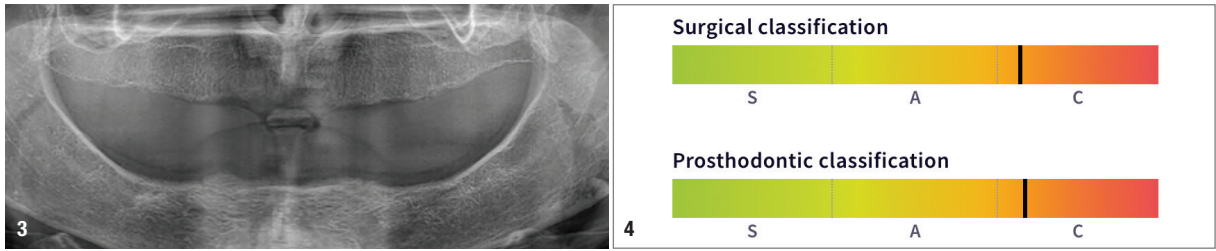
Initial radiographic evaluation by dental panoramic tomogram. Fig. 4: The SAC classification of the treatment.
